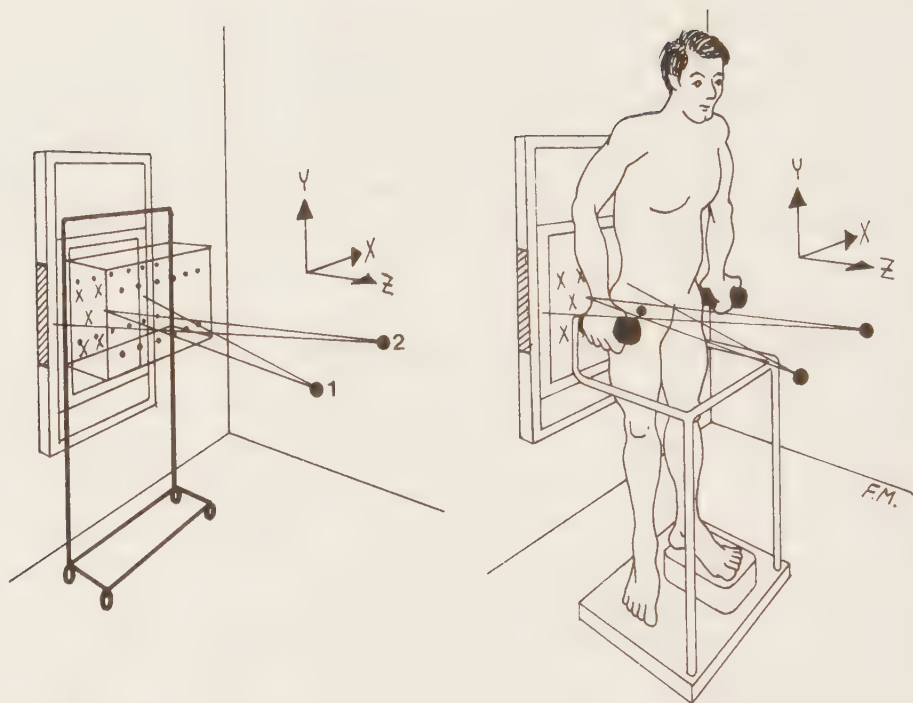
Unloaded stereo roentgen examination of the right hip. The stereo roentgen set-up is first calibrated using a test object with tantalum markers in two planes. In front of the film a reference plate with tantalum markers (shown for focus 2) is fixed and these markers are used to relate film co-ordinates in patient investigations to the laboratory co-ordinate system.
